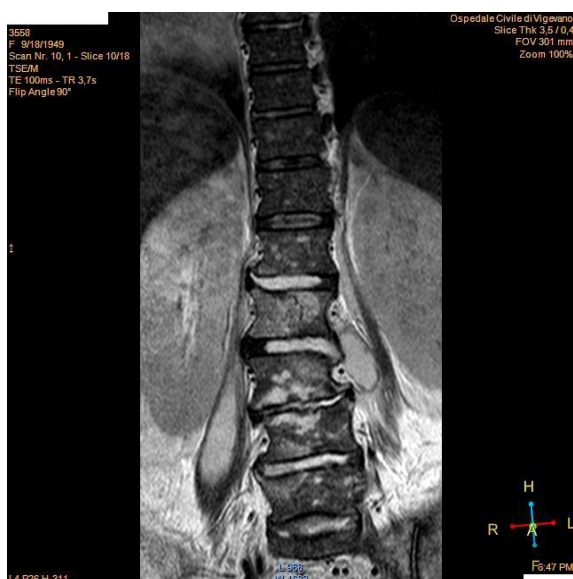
MRI sagittal cut showing hyperintense and inhomogeneous signal in lumbar tract and Psoas Abscess during empiric antibiotic therapy.
